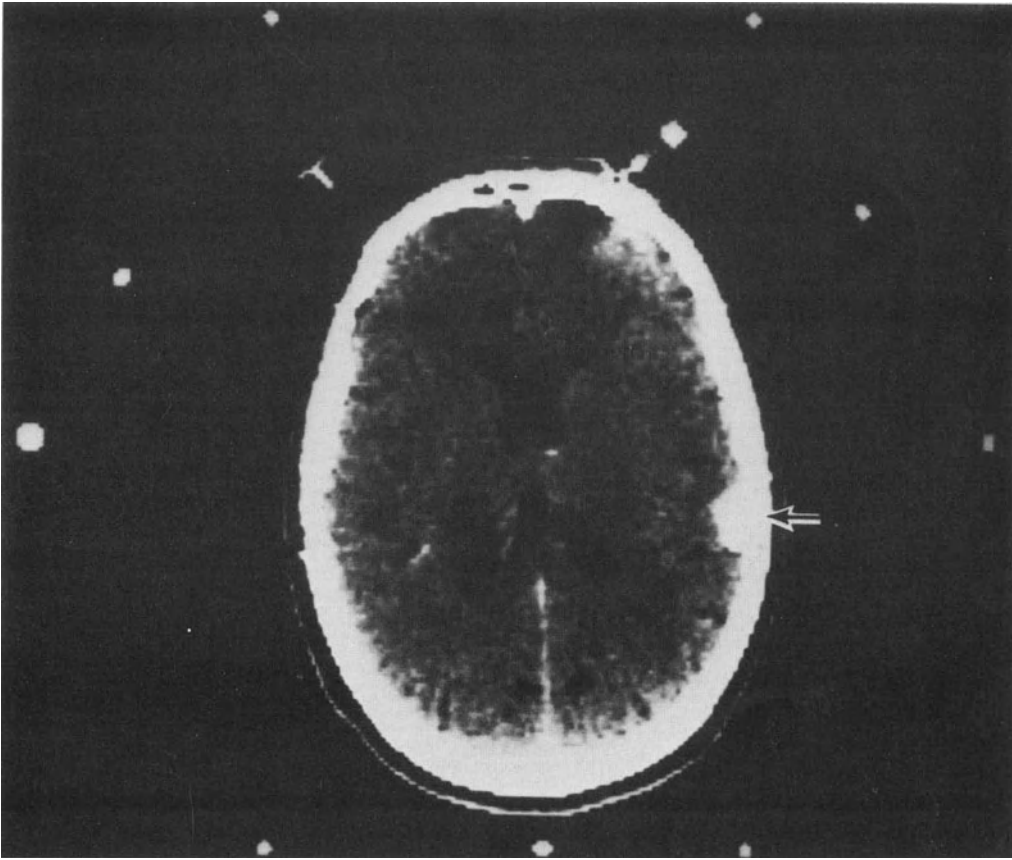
CT scan localizing the small surface meningioma (*arrow*).
